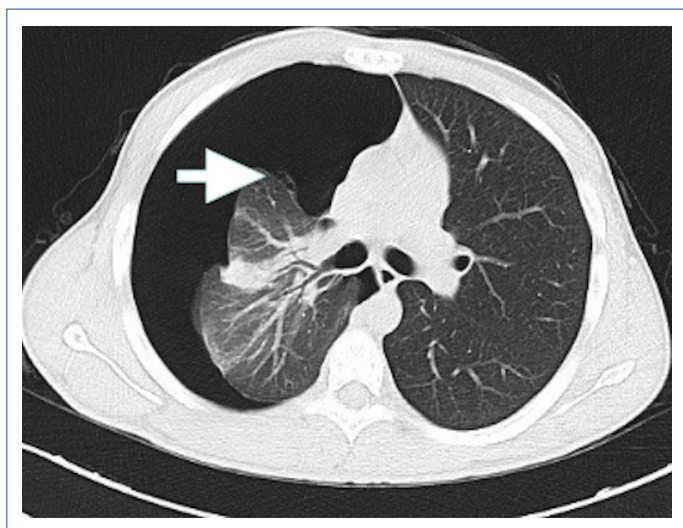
CT image of the bleb.
